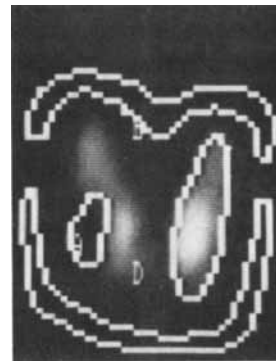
From the simultaneous technetium scintigram (Fig. 1, left) the pathological, normal and background areas are primarily defined for the subsequent kinetic analysis of recorded thallium uptake.
